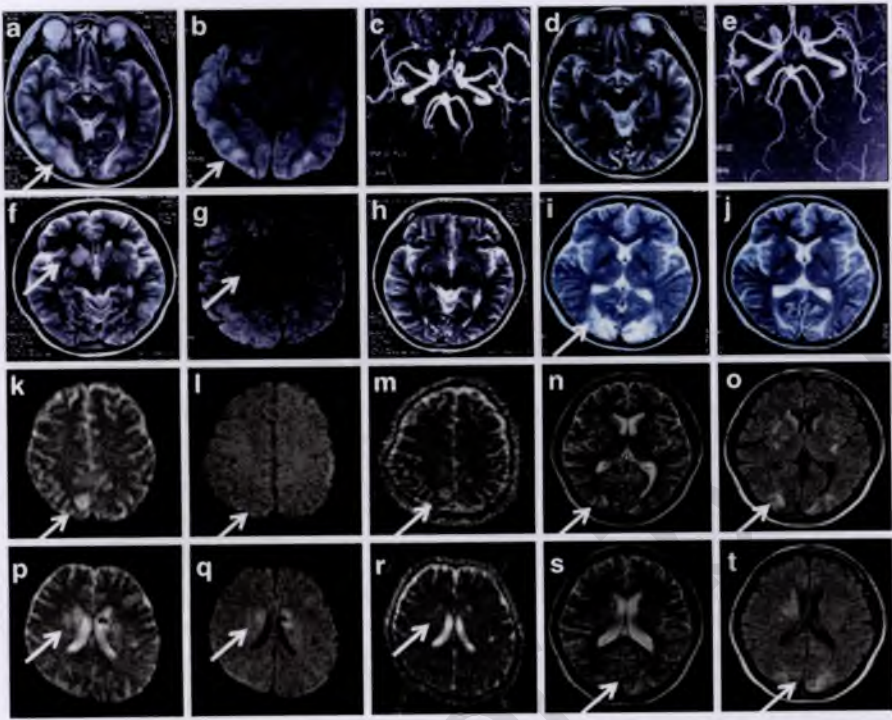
MRI scans of eclampsia. (a–e) A 31-year-old Japanese primigravida woman who was complicated with convulsions and impaired consciousness at 4 h after delivery. Cytotoxic brain edema in the bilateral occipitoparietal lobes and cerebrovascular spastic changes were seen on T₂WI (a), DWI (b), and MRA (c), which were performed the day after the convulsions. The cytotoxic brain edema had disappeared by 31 days postpartum (d, e). (f–h) Case 1. Vasogenic brain edema was observed in the bilateral putamina and pons on T₂WI (f) and DWI (g) scans obtained 60 min after the second episode of convulsions. It had disappeared by 36 days postpartum (h). (i, j) A 39-year-old Japanese primigravida woman who was complicated with preeclampsia and developed convulsions after a cesarean section at 32 weeks' gestation. Brain edema was seen in the bilateral occipital lobes on T₂WI performed just after the convulsions (i). It had disappeared at 8 days postpartum (j). (k–m) A 31-year-old Japanese primigravida woman who was complicated with preeclampsia and convulsions just before delivery. Vasogenic edema was noted in the right occipital lobe on T₂WI (k), DWI (l), and ADC (m) mapping scans performed at 2 h after delivery. Iso-low intensity DWI signals and high ADC are indicative of vasogenic brain edema. (n, o, s, t) A 32-year-old Japanese primigravida woman who was complicated with convulsions and placental abruption during labor. Multifocal brain edema was seen on T₂WI (n, s) and FLAIR (o, t) scans performed at 2 days after the patient underwent a cesarean section. As shown by these images, FLAIR was better than T₂WI at depicting the periventricular lesion. (p–r) A 30-year-old Japanese multigravida woman who was complicated with preeclampsia, convulsions, and HELLP syndrome at 5 h after delivery. Vasogenic edema was observed in the right occipital lobe on T₂WI (p), DWI (q), and ADC (r) mapping scans performed at 1-day postpartum. High-intensity DWI signals and high ADC are indicative of vasogenic brain edema (T₂ shine-through). Arrow, site of the brain edema
